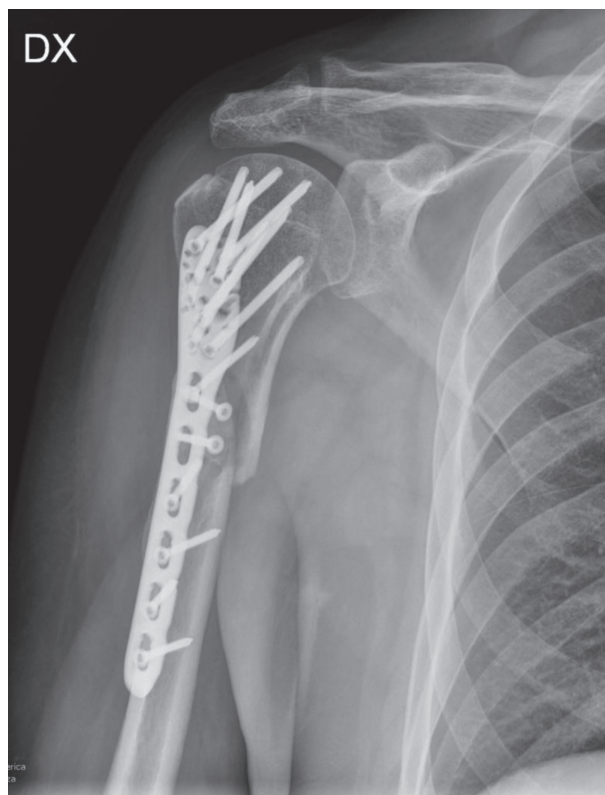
Four months follow up x-ray (AP view - intrarotation)
